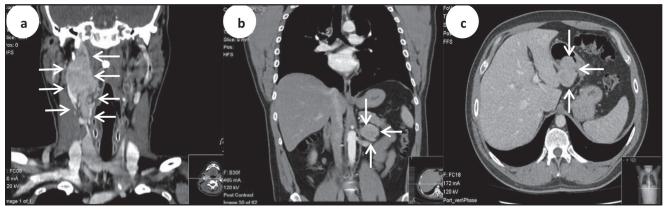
The patient's contrast computed tomography images. (A) Saggital view of the neck showed a right carotid body PGL (B) Saggital view of the abdomen revealed a left supra-adrenal PGL (C) Coronal view of the abdomen showing the GIST, which protruded from the posterior wall of the stomach (white arrows = lesions). GIST = gastrointestinal stromal tumor, PGL = paraganglioma.
